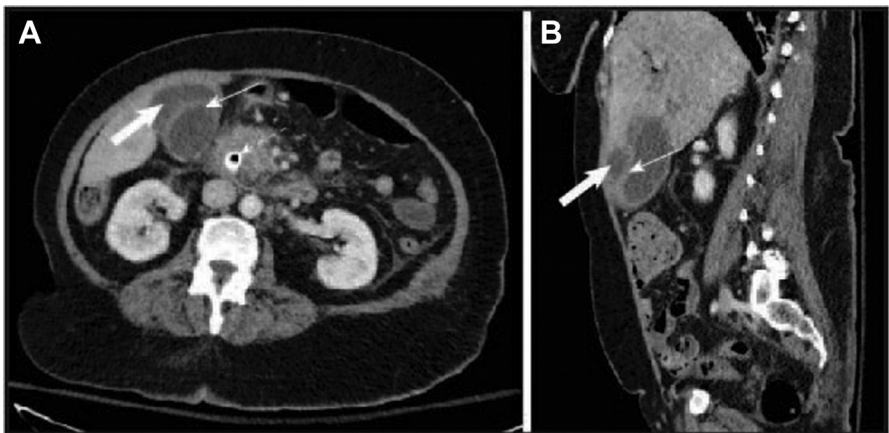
Perforated gallbladder on computed tomography. (A) Transverse image showing fluid collection (*thick arrow*) adjacent to the gallbladder with thickened wall (*thin arrow*). Pancreatic stent placed because of coexisting malignancy also visible (*dashed arrow*). (B) Sagittal image showing fluid collection (*thick arrow*) anterior to gallbladder with thickened wall (*thin arrow*).
